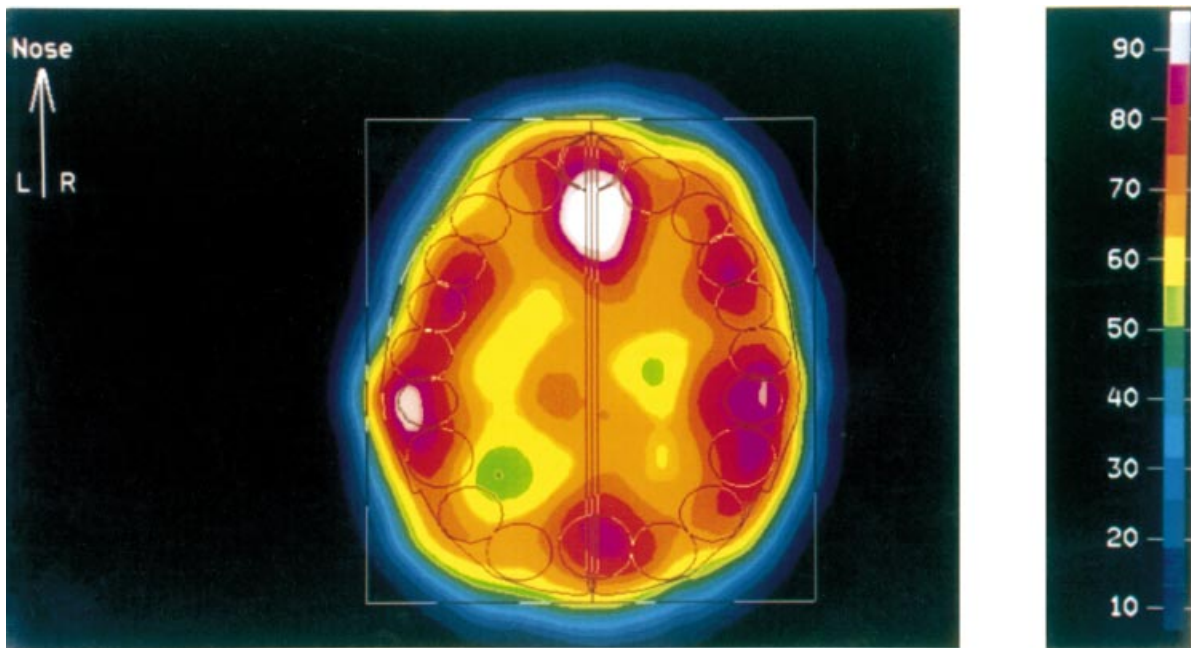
Image of rCBF obtained at the level OM + 60 mm (60 mm over the orbitomeatal plane) using ^{133}Xe and dynamic SPECT. The colour scale represents the absolute values of rCBF expressed in ml/min/100 g. The circular regions of interest are symmetrically drawn by the computer on the cortical ribbon of each hemisphere.
